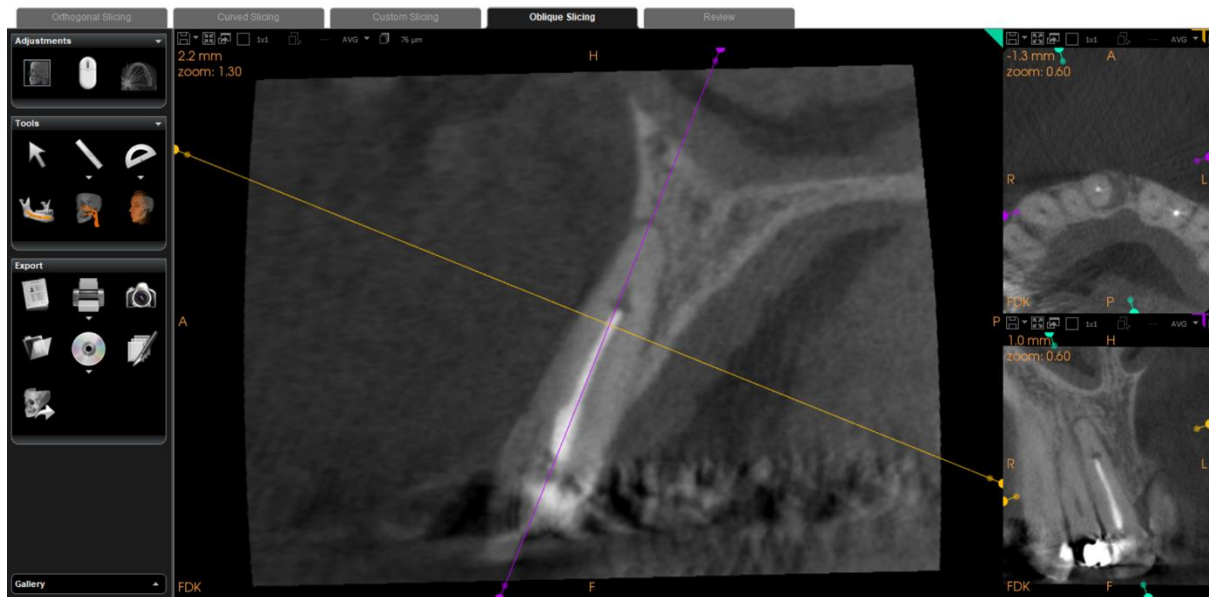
cone beam computed tomography images displayed using viewing software.
